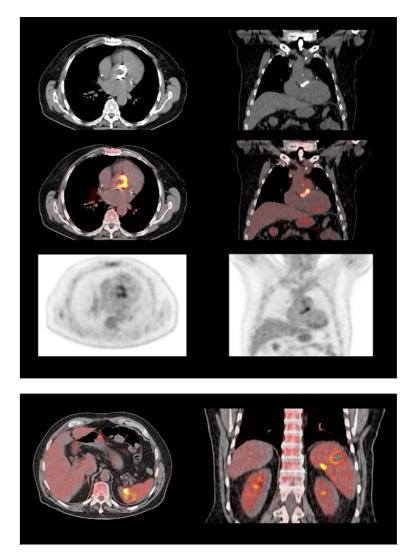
Transverse and coronal ¹⁸F-FDG PET/CT images show an infected prosthetic aortic valve (A). The culture after valve removal was positive for *Propionebacterium acnes*. Fusion PET/CT images also demonstrate septic spleen embolisms (B).
